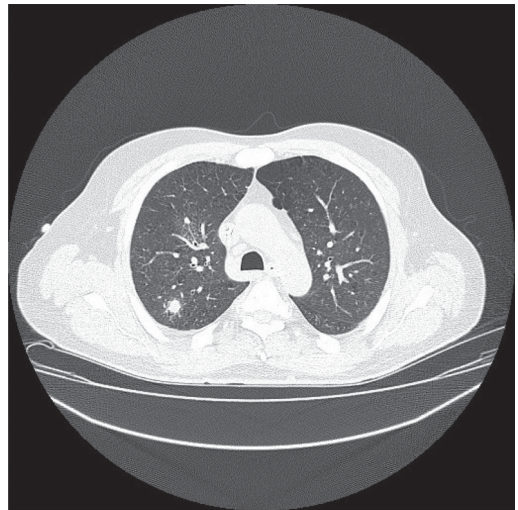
CT scan demonstrates a small dense nodule in the peripheral of the lung. The nodule in the right lung has a halo surrounding it.
